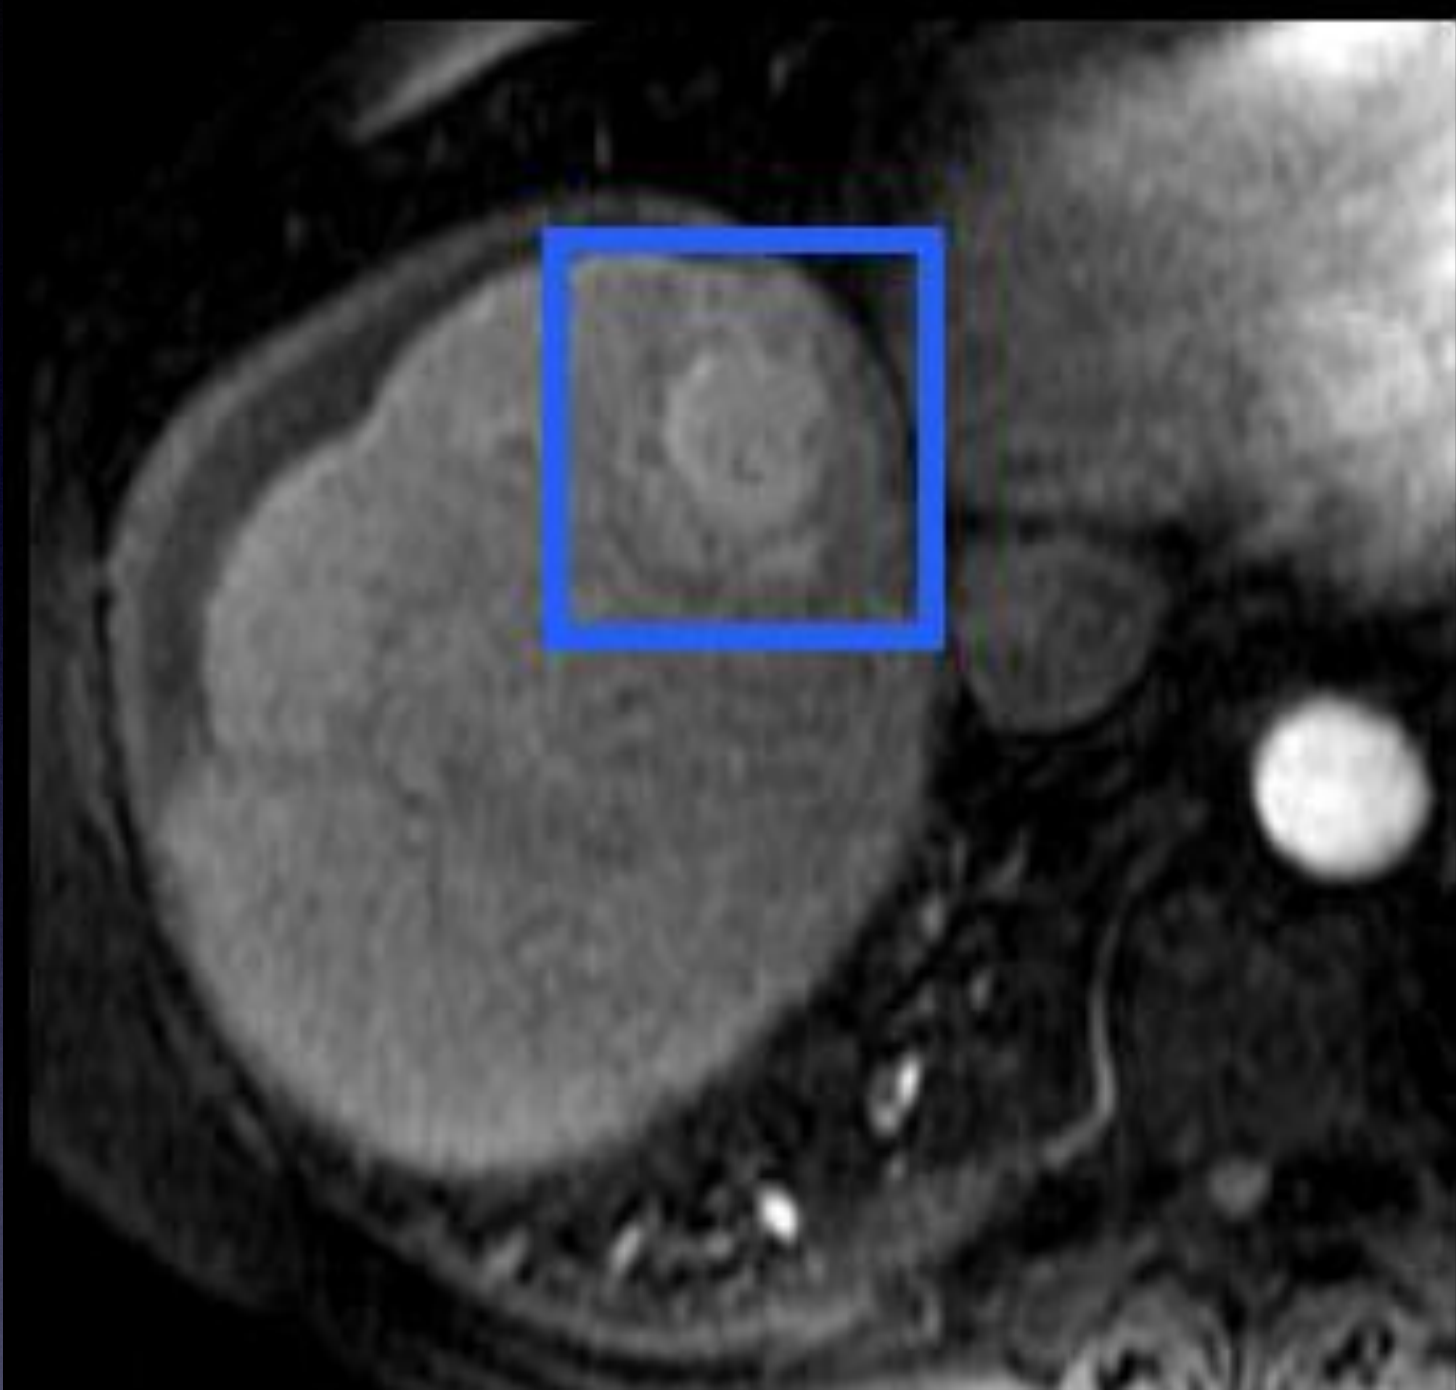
Dynamic computed tomography scan of a patient with hepatocellular carcinoma showing no lesion in the noncontrast phase, an enhancing lesion in the arterial phase of contrast administration, and a faint lesion in the portal venous phase seen better in the delayed phase.
